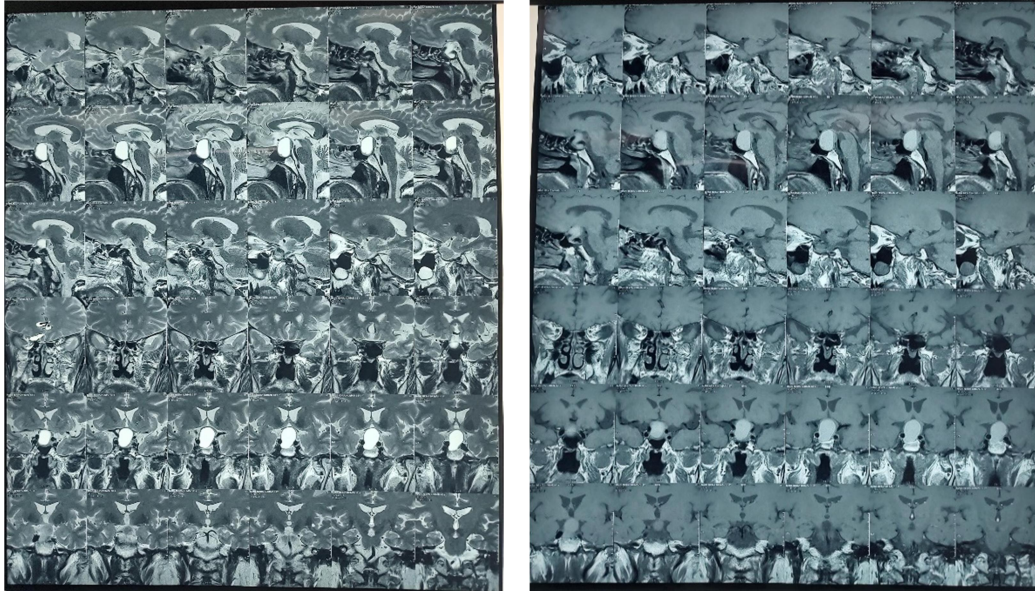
MRI Brain showing Pituitary macroadenoma/apoplexy
